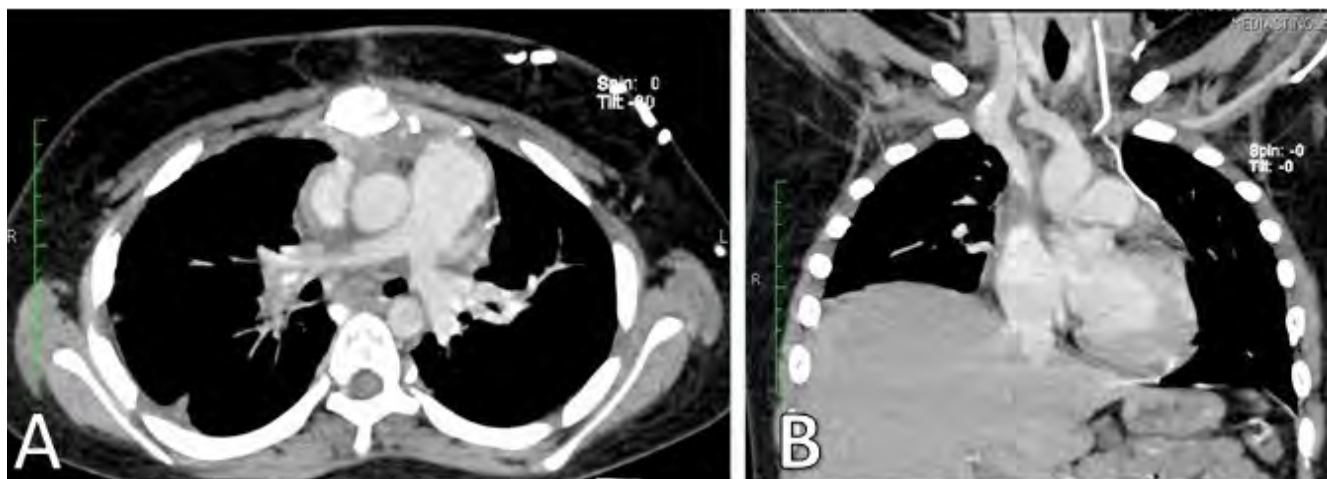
A. Contrast chest CT where the permeability of the right pulmonary artery is observed after surgical reconstruction. B. Contrast coronal section CT scan showing the permeability of the superior vena cava after the surgical reconstruction.
